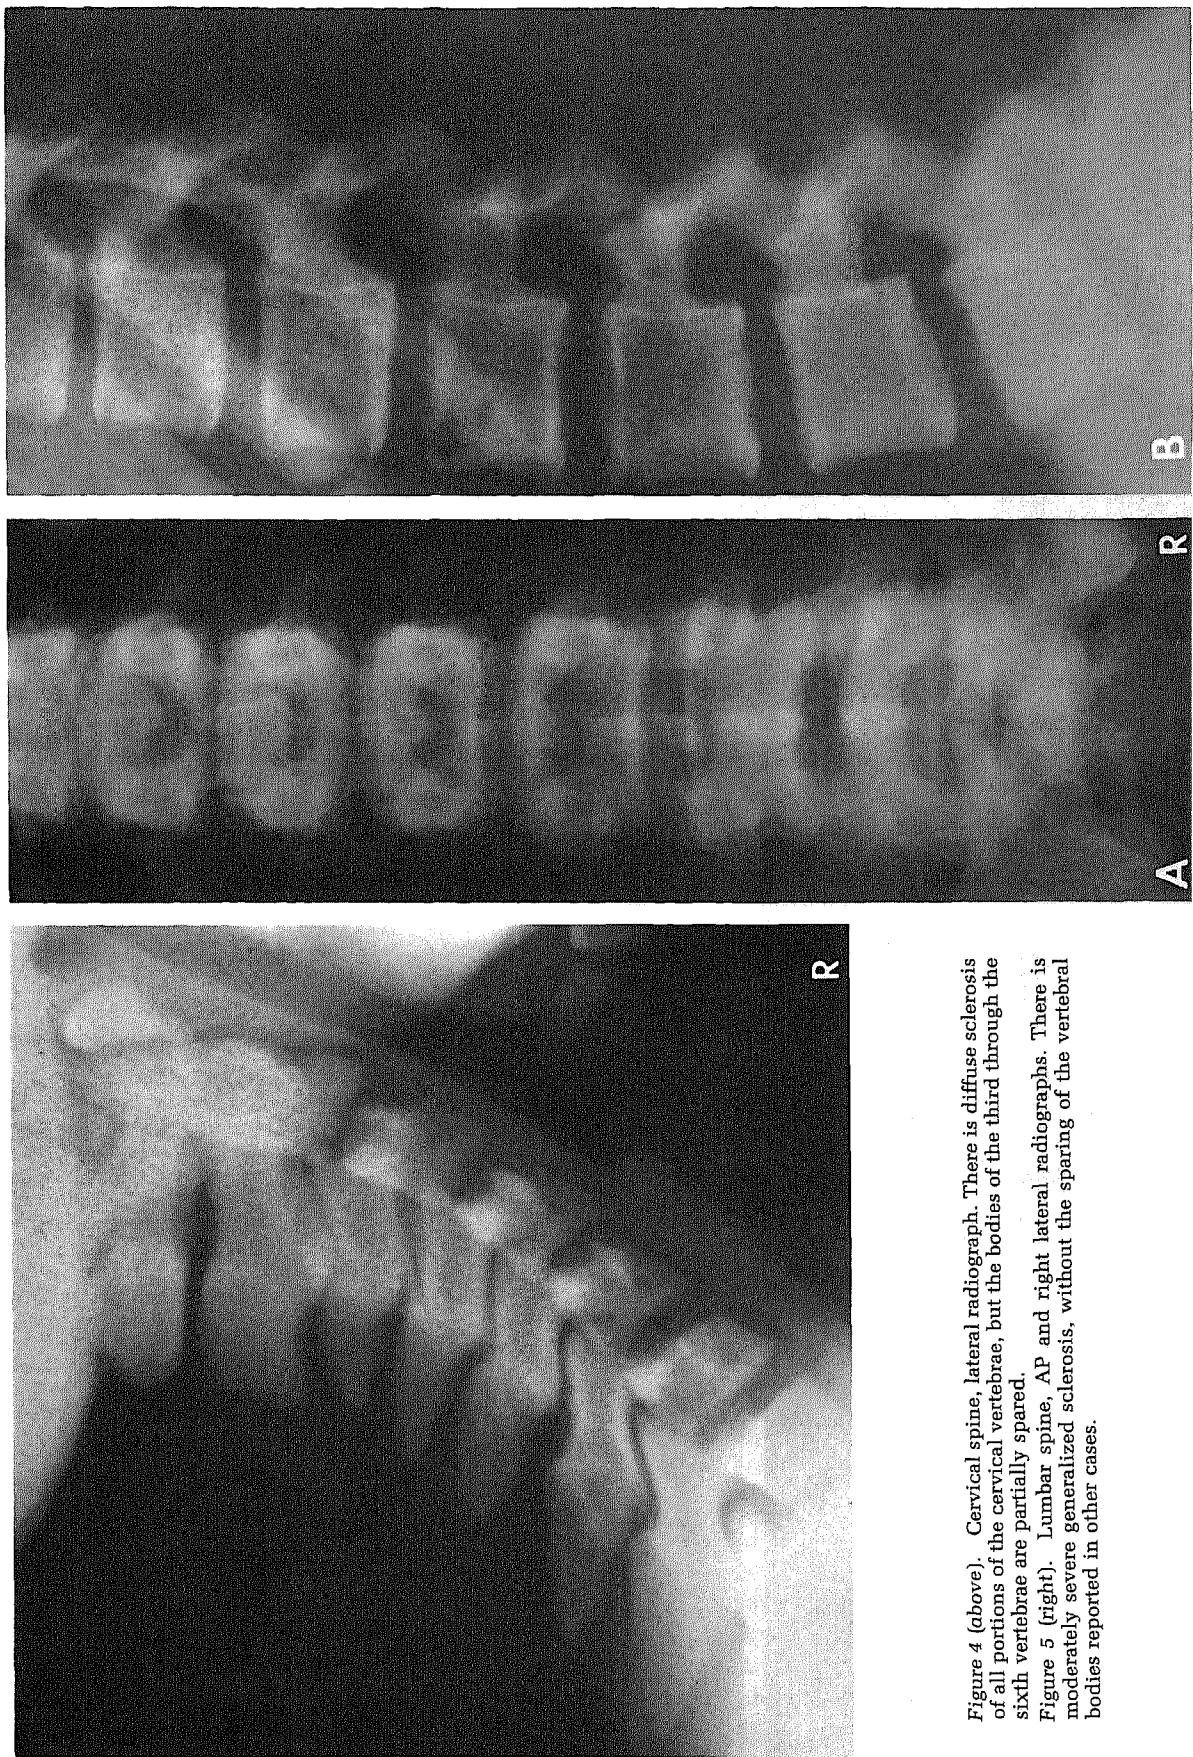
(above). Cervical spine, lateral radiograph. There is diffuse sclerosis of all portions of the cervical vertebrae, but the bodies of the third through the sixth vertebrae are partially spared.
